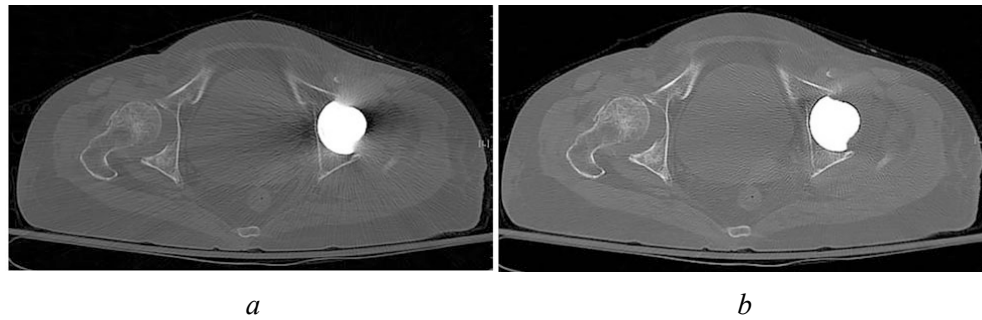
CT image reconstructed without (a) and with (b) the O-MAR technique (Jiwon Rim *et al.*, the image is licensed under CC BY-NC 4.0)[17, p. 23]
